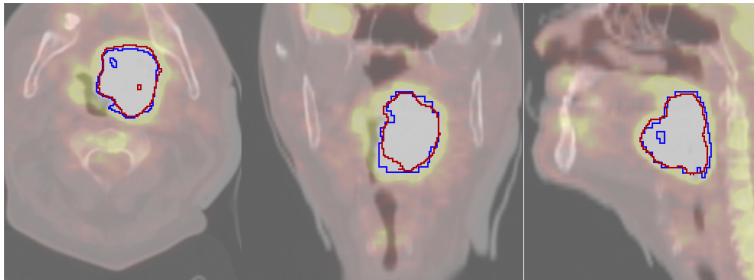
Example of a *manual* GTVt in blue and the UNet-generated *automatic* GTVt in red on a fused PET/CT image.
